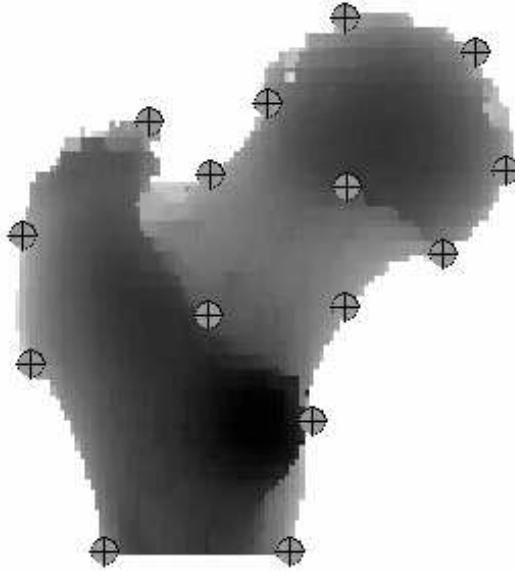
Landmarks on a femur radiograph
